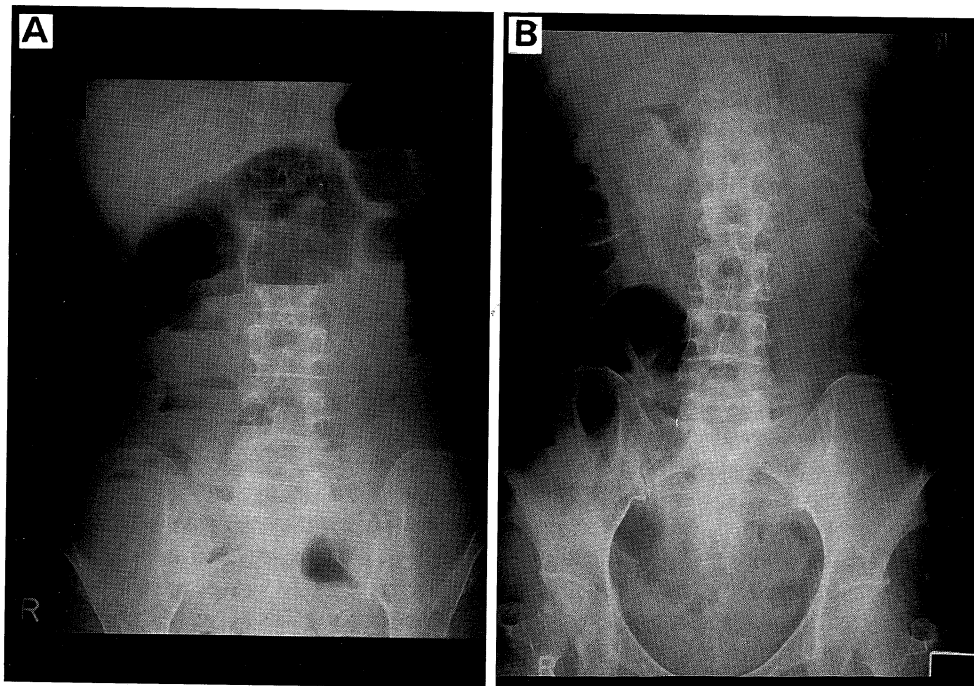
Case 2. A: A roentgenogram (before octreotide treatment) showing numerous air-fluid levels B: Air-fluid levels were decreased by octreotide acetate. A roentgenogram was taken on day 14 of treatment.
